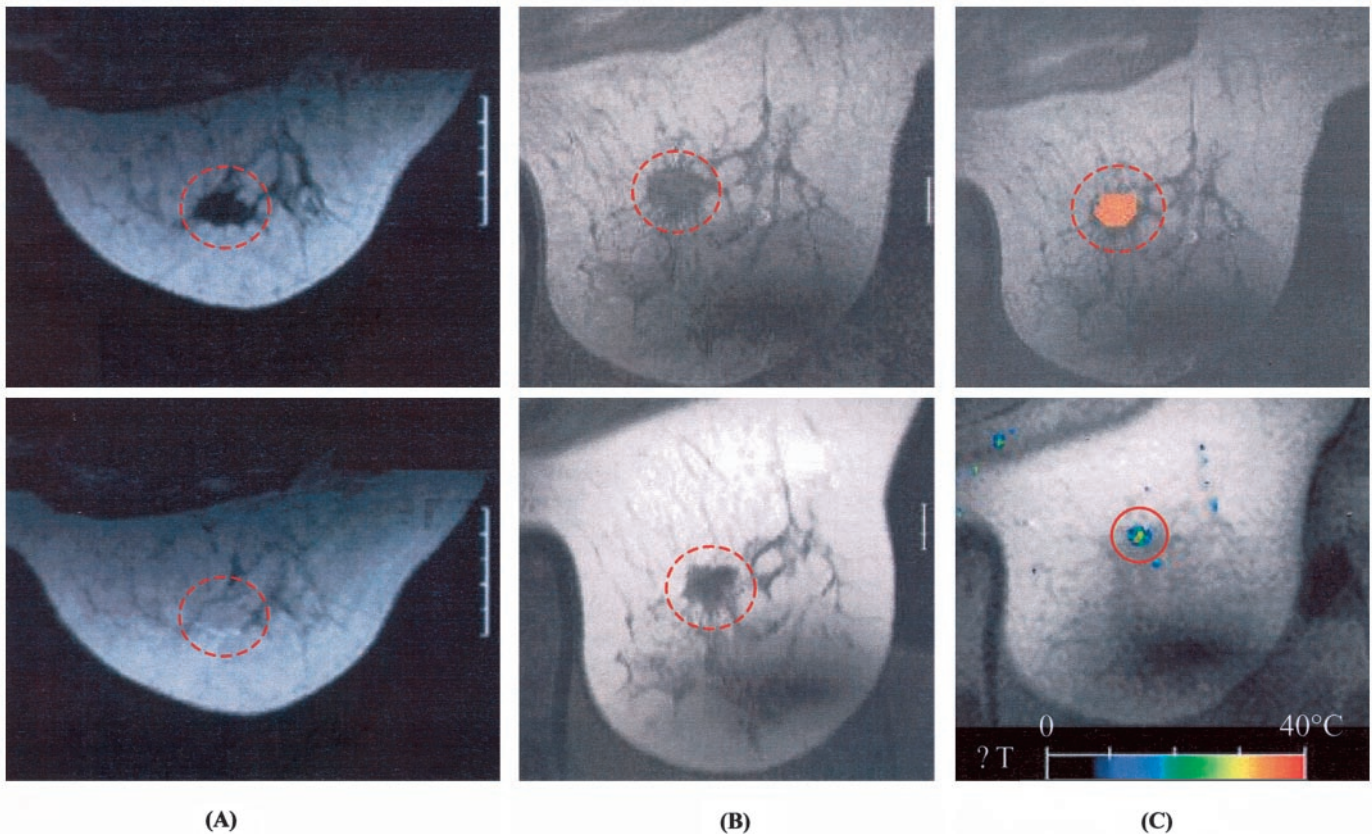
A, T1w MRI mammography of a biopsy-confirmed breast cancer in a standard breast coil 2 days before ultrasound therapy, without i.v. contrast (*top*) and after i.v. contrast (*bottom*), showing strong tumor contrast enhancement. B, T1w MR images in the ultrasound treatment unit: immediately before, *i.e.*, without i.v. contrast (*top*), and after therapy with i.v. contrast (*bottom*), exhibiting a complete lack of contrast enhancement after FUS therapy. C, T2w MRI treatment planning with definition of 80 foci (*top*) and MRI thermometry during sonication with color-coded temperature distribution after treatment (*bottom*).
